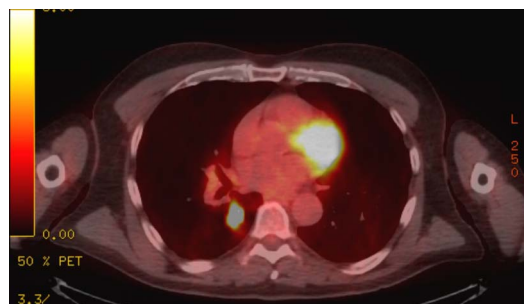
Transaxial plane of the positron emission tomography-CT scan demonstrates fluorodeoxyglucose-avid hypermetabolic lesion adjacent to the right hilum.
